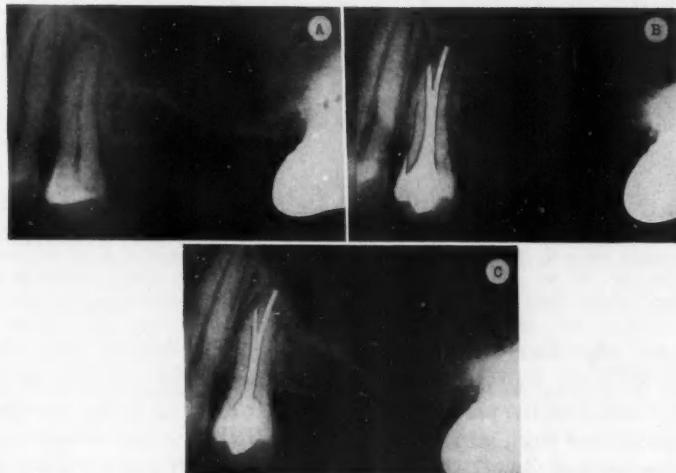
Roentgenograms of a maxillary left second bicuspid demonstrating obturation of a bi-root bicuspid using the single silver cone technique. *A*, At initiation of therapy. *B*, At completion of obturation. *C*, One year after completion of therapy, demonstrating complete resolution of apical pathosis.
